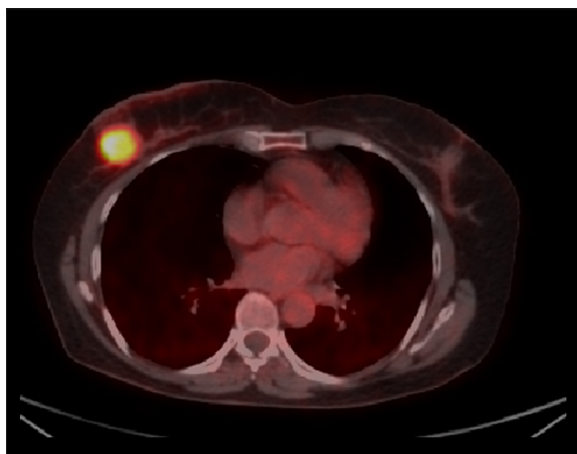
Axial FDG-PET/CT image of a LABC patient with a mass in the right breast. Tumoural SUV_{max} was 10.0.
